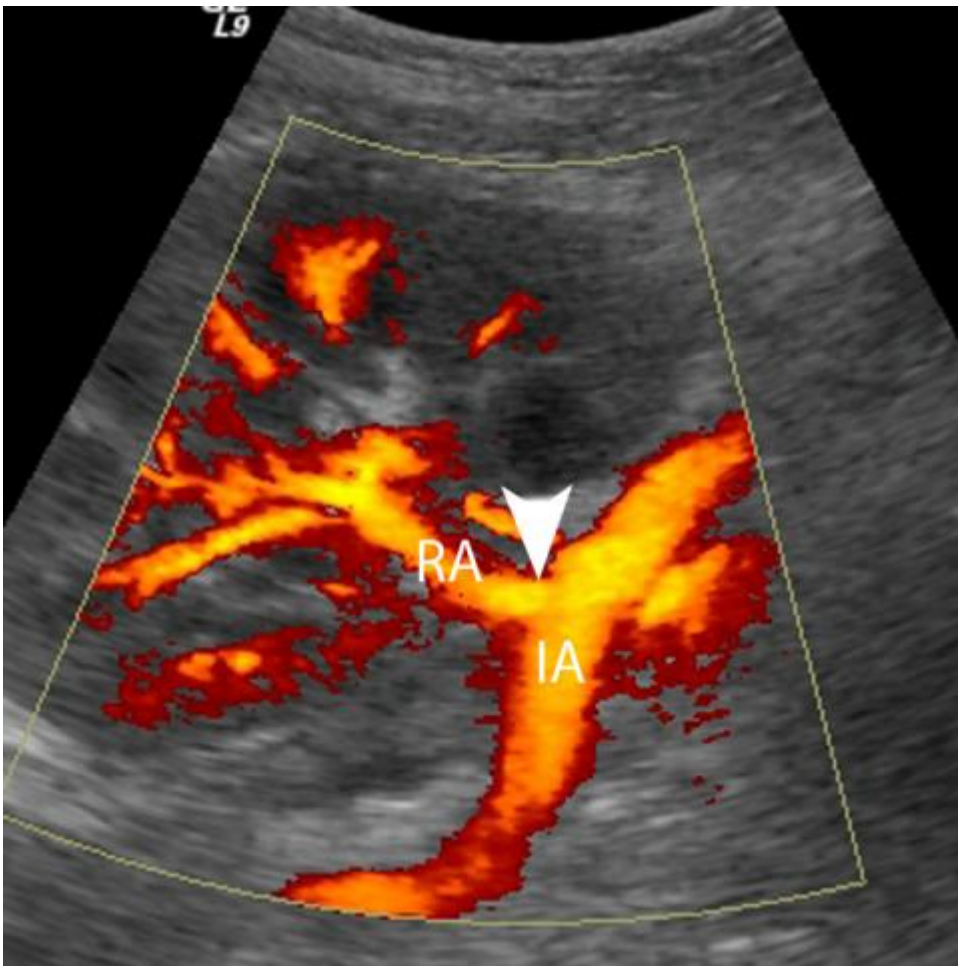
Normal renal transplant anatomy. Power Doppler image shows the renal transplant in the right iliac fossa. The end-to-side anastomosis (arrowhead) between the transplanted renal artery (RA) and the recipient's external iliac artery (IA) is well shown.
